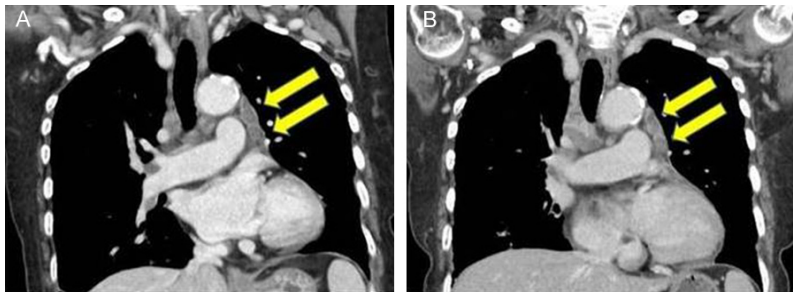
A. Initial CT radiograph (coronal sections) showing involvement of multiple lymph nodes in the mediastinal area (arrows); B. Second CT radiograph performed after completion of chemotherapy before the operation showing no effect on mediastinal LN lesions (arrows).
